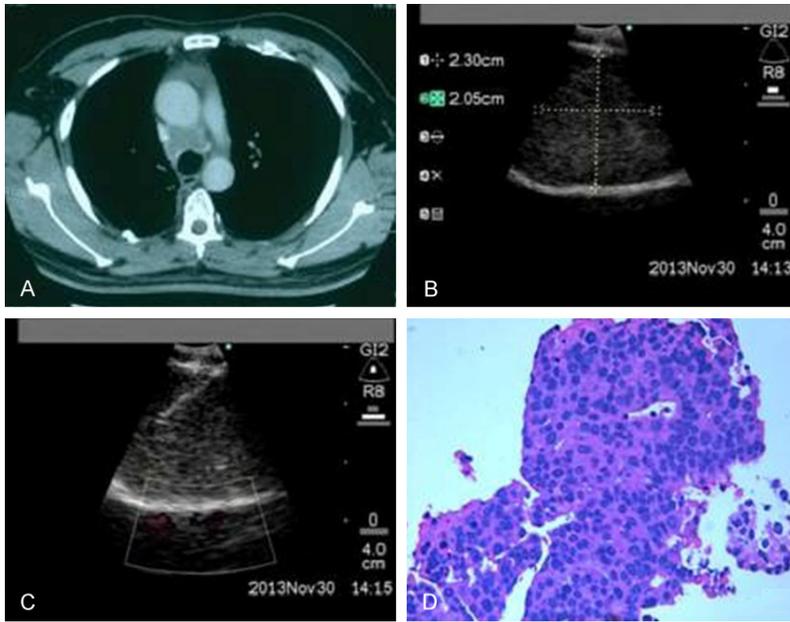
Example of detailed diagnosis process of individual patient. A. The patient, male, 64 years old, had enlargement of 4R lymph node indicated by chest CT. B. The position and diameter of 4R lymph nodes were measured by ultrasonic bronchoscope. C. Guided by bronchoscope, the TBNA imaging indicated the puncture needle had entered the 4R lymph nodes. D. The biopsy tissue was confirmed as adenocarcinoma cells by pathological examination.
